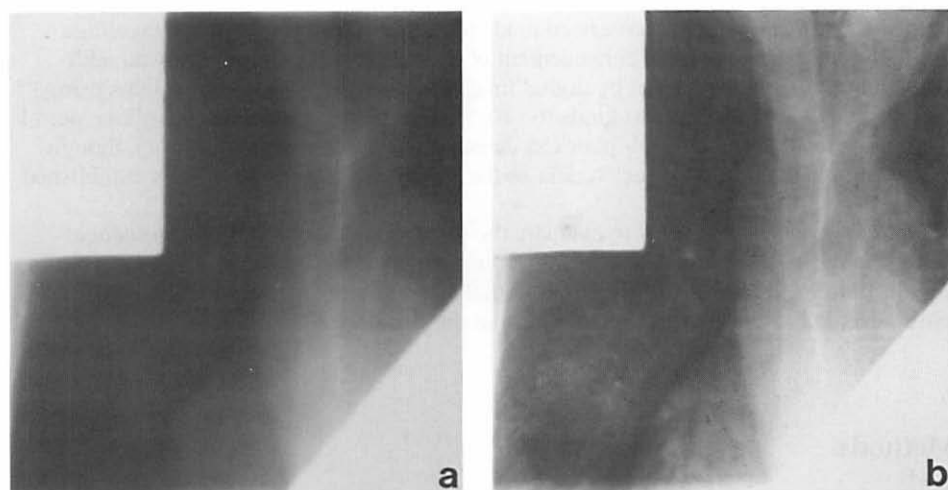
AP field for irradiation (8 MV photons) of lung and mediastinum of a patient with lung cancer. Conventional film-screen technique (a) and computed radiography image (b). Note the increased contrast and visualization of the paracardial mass and the bony structures on the digital image (b).
